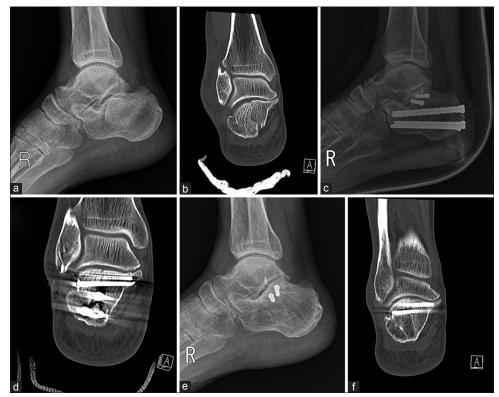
A case of a 60-year-old male patient. (a) Preoperative radiograph of ankle joint lateral view showing a calcaneal fracture with joint depression. (b) Preoperative computed tomography showing calcaneal fracture with Sander's Type 2A. (c) Immediately postoperative radiograph lateral view showing a well-reduced calcaneal fracture using 7.0-mm cannulated screws. (d) Immediately postoperative computed tomography showing an anatomical reduction of a posterior facet. (e) Postoperative radiograph of ankle joint lateral view taken at 1 year after surgery showing complete bony union. (f) Postoperative computed tomography taken at 1 year after surgery showing complete bony union.
